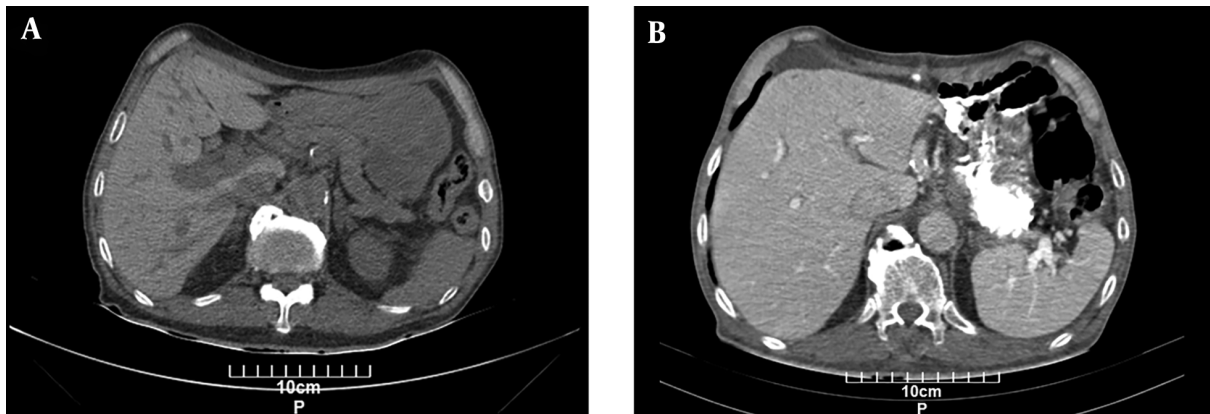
A, preoperative CT without contrast showing a mass of distal part of the stomach; B, postoperative CT with intravenous (IV) and oral contrast showing remained stomach
